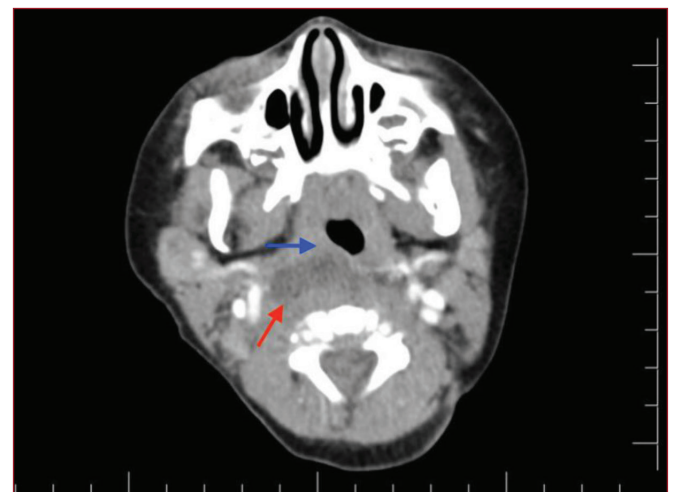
Axial slice of a neck CT scan showing a retropharyngeal abscess (red arrow) and a slight displacement of the airway (blue arrow)
